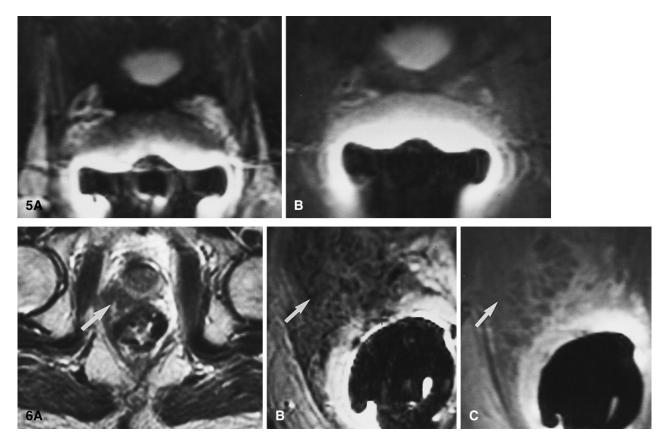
A 68-year-old patient with slightly increased PSA levels. A local recurrence was excluded by MRI and biopsy. A Axial T2-weighted endorectal coil image: at the level of the vesico-urethral anastomosis, a low signal intensity ring suggests concentric scar formation. B Axial contrast-enhanced T1-weighted endorectal coil image demonstrates the lack of pathologic enhancement, thereby excluding tumor recurrence.
